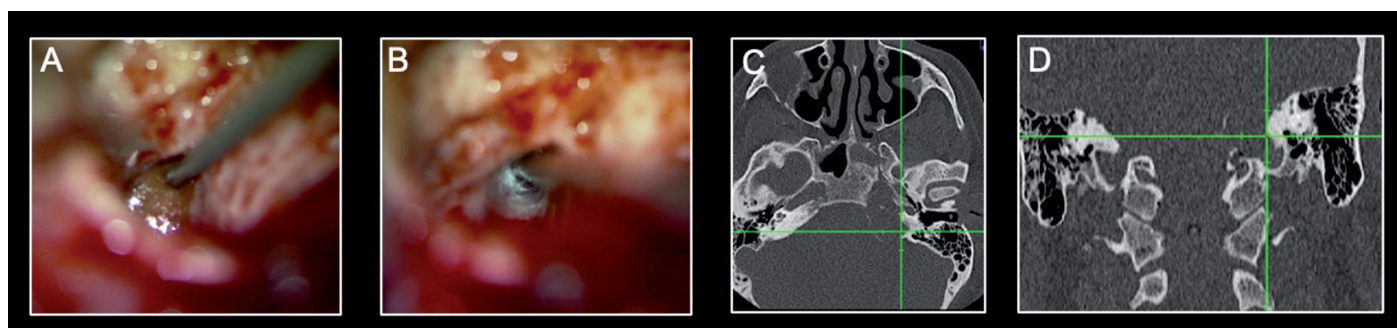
a-d. Intraoperative findings with corresponding CT-navigation (A and C) at the point of entry at the lateral wall of the PACG after mastoidectomy with subsequent drainage. (B and D) Identifying most medial wall of the PACG. CT, computed tomography.
